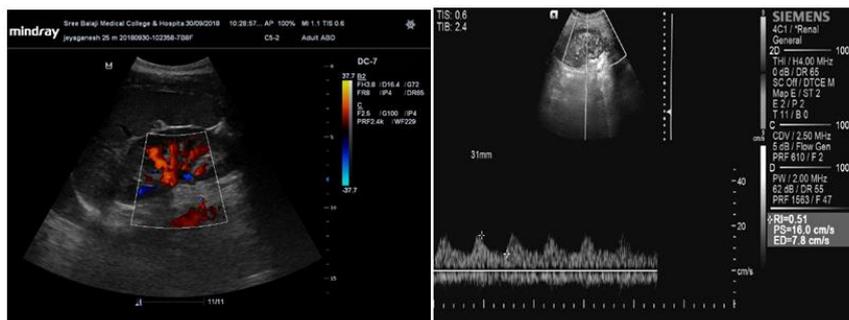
Show colour Doppler study of the kidneys with measurement of resistive index
